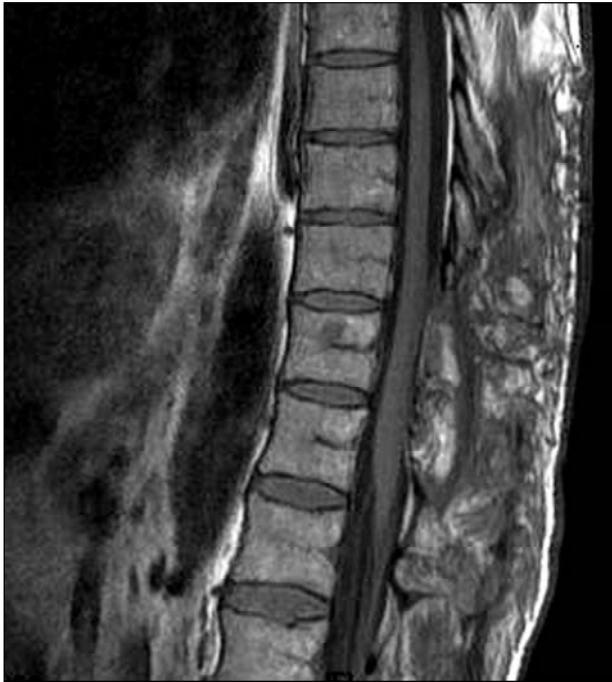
Postoperative T1-weighted sagittal spinal MRI shows the resolution of the pseudomeningocele.
